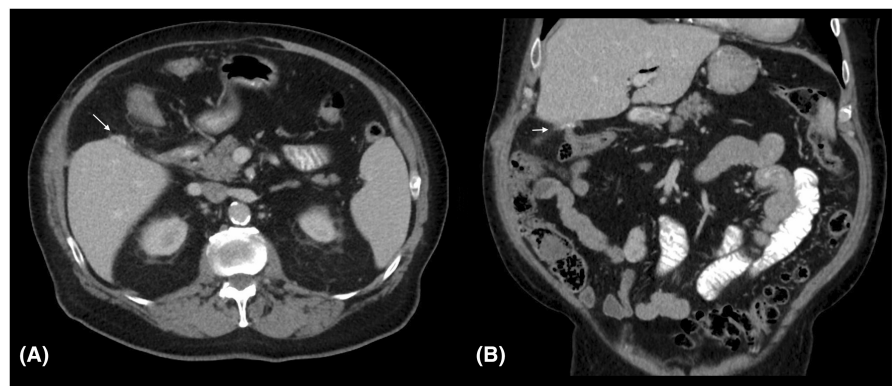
Postoperative CT imaging 1 year following surgery demonstrating durability of the omental pedicle plug in collapsing the gallbladder lumen (arrows). (A) Axial. (B) Coronal.
